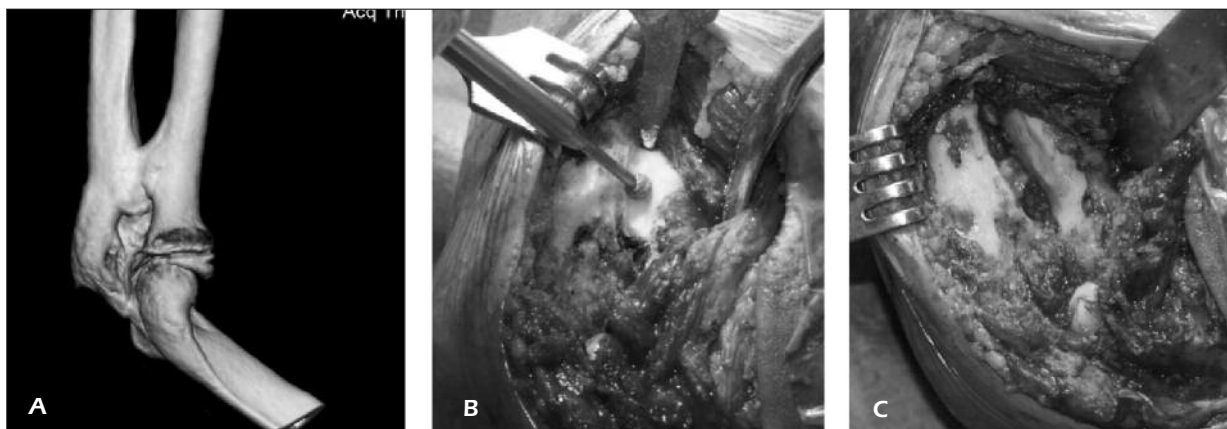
A*, Preoperative 3D reconstructed CT volume (VRT) depicting proximal radio-ulnar synostosis and malunited olecranon fracture. *B*, Intraoperative aspect while burring of the osseous bridge. *C*, Final result which permits prono-supination.
